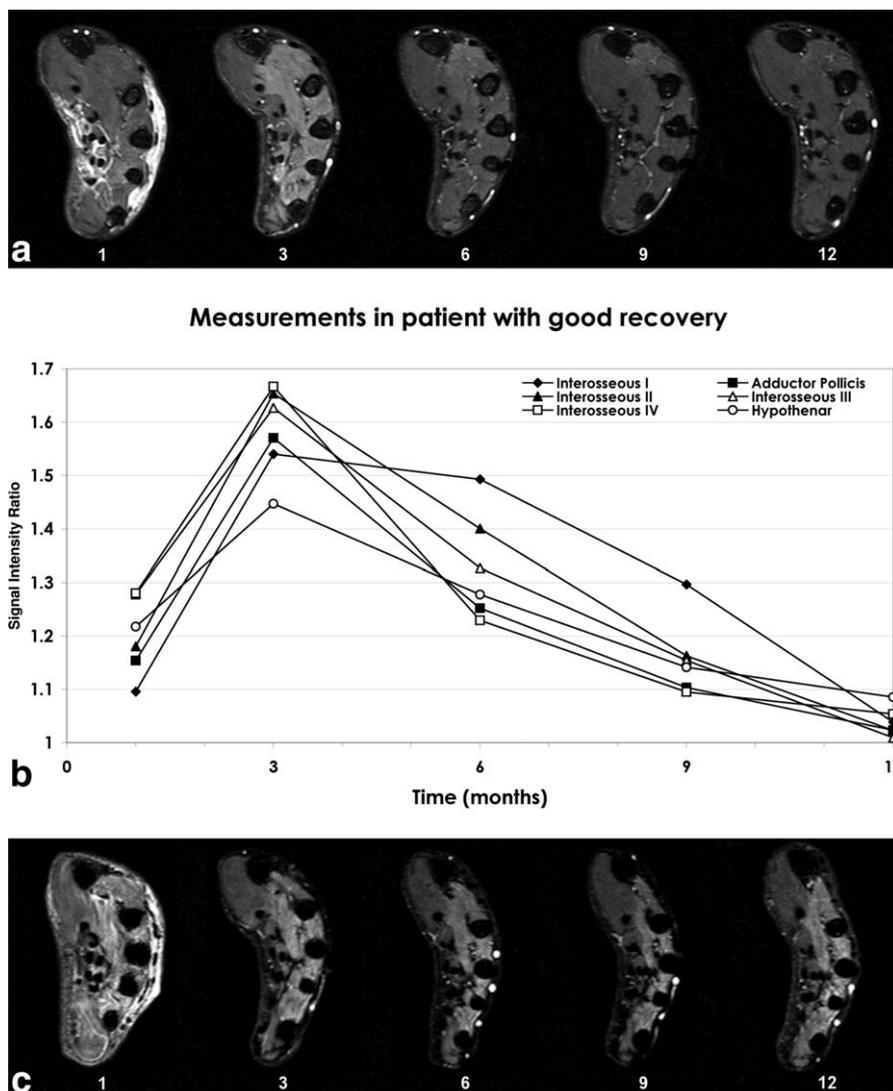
a: Standardized, signal corrected STIR-MRI scans in a patient with full function recovery after ulnar nerve repair, at 1-, 3-, 6-, 9-, and 12-months follow-up. Notice the distinct swelling and subcutaneous edema at 1 month, while at 3 months signal intensities of the denervated adductor pollicis, interosseous and hypothenar muscles are markedly increased compared with the thenar muscle. It can be seen that signal intensities of the hypothenar and interosseous muscles at the ulnar side normalize at 6 months, with remaining high signal intensities in the first and second interosseous and adductor pollicis muscles. At 9 months, the first interosseous muscle still shows slight signal intensity increase, while at 12 months, all signal intensities returned to normal. b: Measurements in the same patient, of the separate muscles, clearly showing that the hypothenar and interosseous muscles IV and III recover before interosseous muscles I and II, thus visualizing the regeneration process from the ulnar side toward the radial side. c: Images of a patient with poor recovery of the ulnar nerve for comparison. Signal intensity remains elevated during the year following surgical nerve repair.
